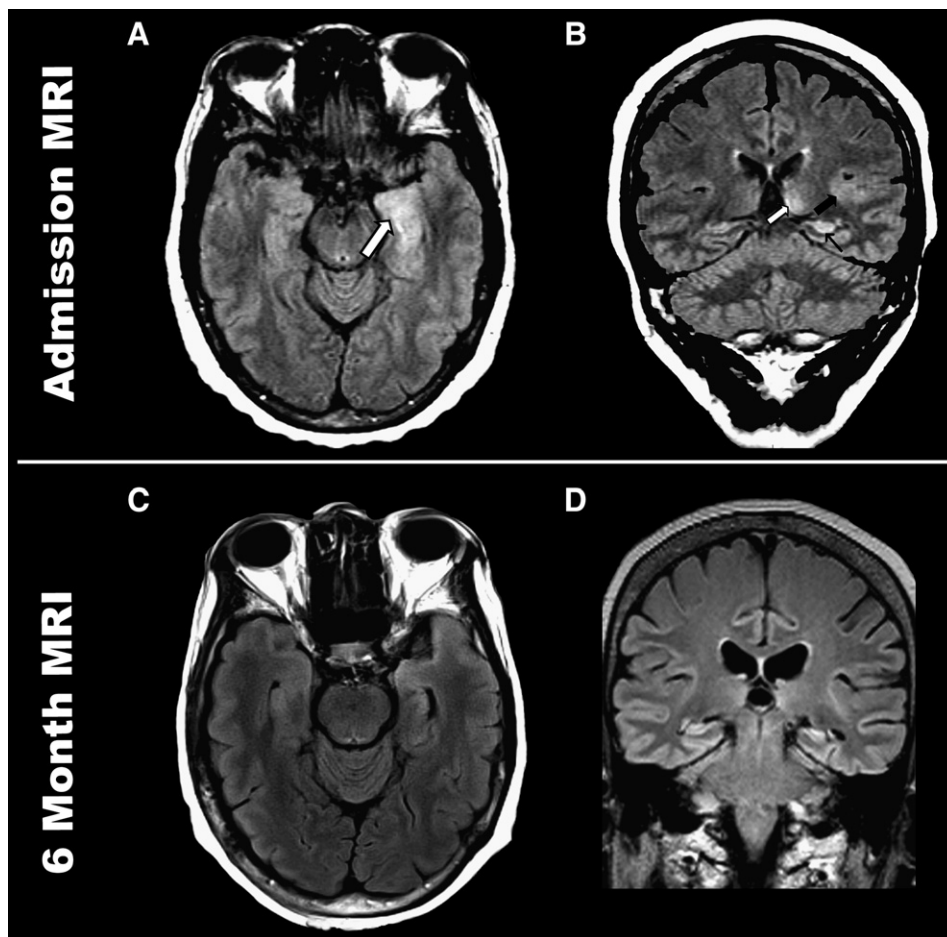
MRI of brain on admission and 6 months later: FLAIR sequences. A: Axial FLAIR image with hyperintensity in the left medial temporal lobe (white arrow). B: Coronal FLAIR image with hyperintensity in the left hippocampus (thin black arrow), thalamus (white arrow), and superior temporal gyrus within the lateral sulcus (thick black arrow). C: Axial FLAIR image 6 months later showing partial resolution of the previous hyperintensity in the left medial temporal lobe. D: Coronal FLAIR image 6 months later showing complete resolution of the increased signal in the left hippocampus, thalamus, and cortex.
